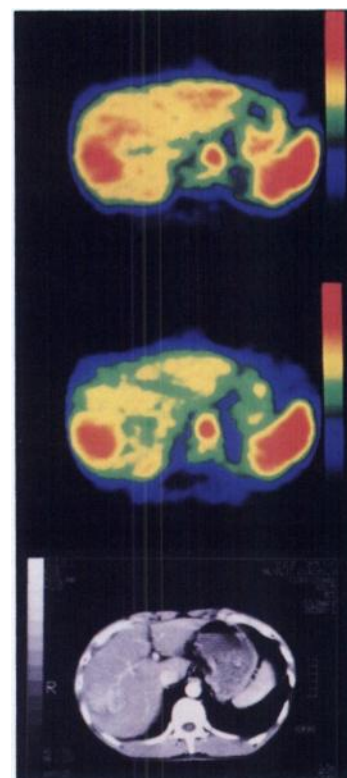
A 49-yr-old man with hepatocellular carcinoma (HCC). Top, middle and bottom images are PET images of normotensive and hypertensive states and a CT scan, respectively. Compared to the normotensive state, PET images show a preferential increase in blood flow to the tumor compared with liver parenchyma, in the hypertensive state.
